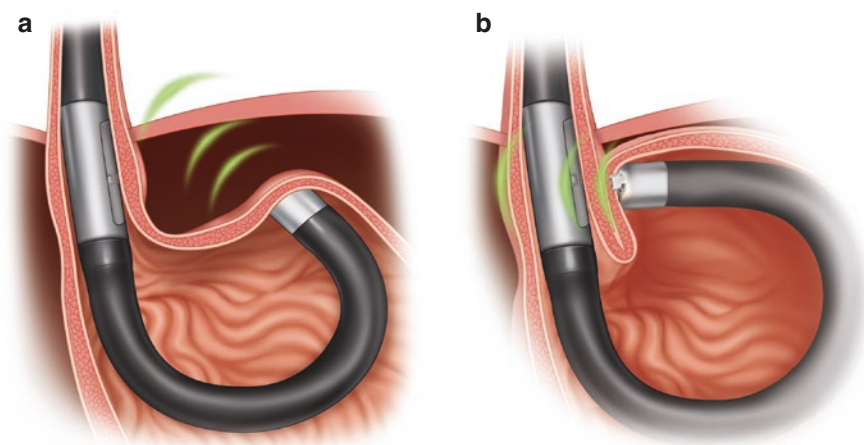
MUSE™ System for the creation of an ultrasound-guided stapled fundoplication
